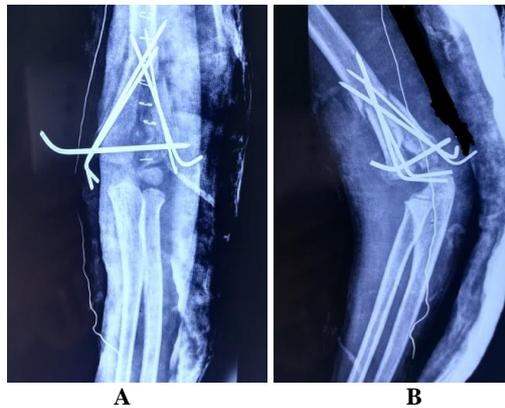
(A, B) Post operative antero-posterior and lateral radiograph of intercondylar fracture distal humerus fixed with K-wires.
